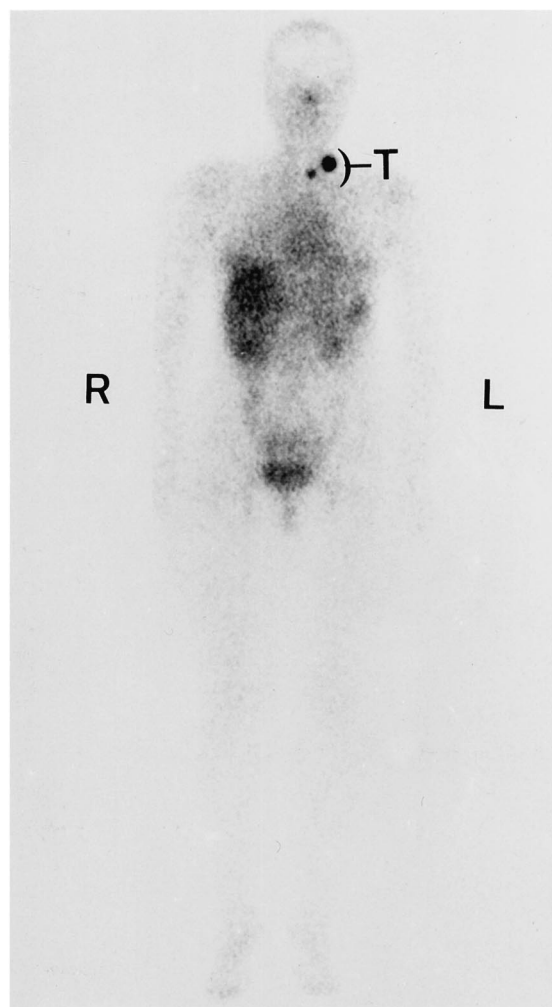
AES immunoscintigraphy whole-body scan (anterior view, patient 3): detection in the neck area of two occult tumors (T), which had escaped conventional morphological imaging. Basal and stimulated calcitonin as well as CEA were restored to normal after surgery (30 months of follow-up).
